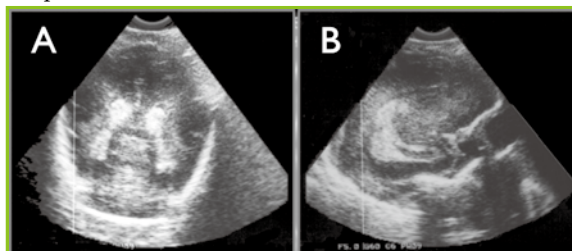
Ultrasound of a neonate with intraventricular haemorrhage. A Axial and B Sagittal view, showing blood in the ventricles as hyperechoic lesion.
